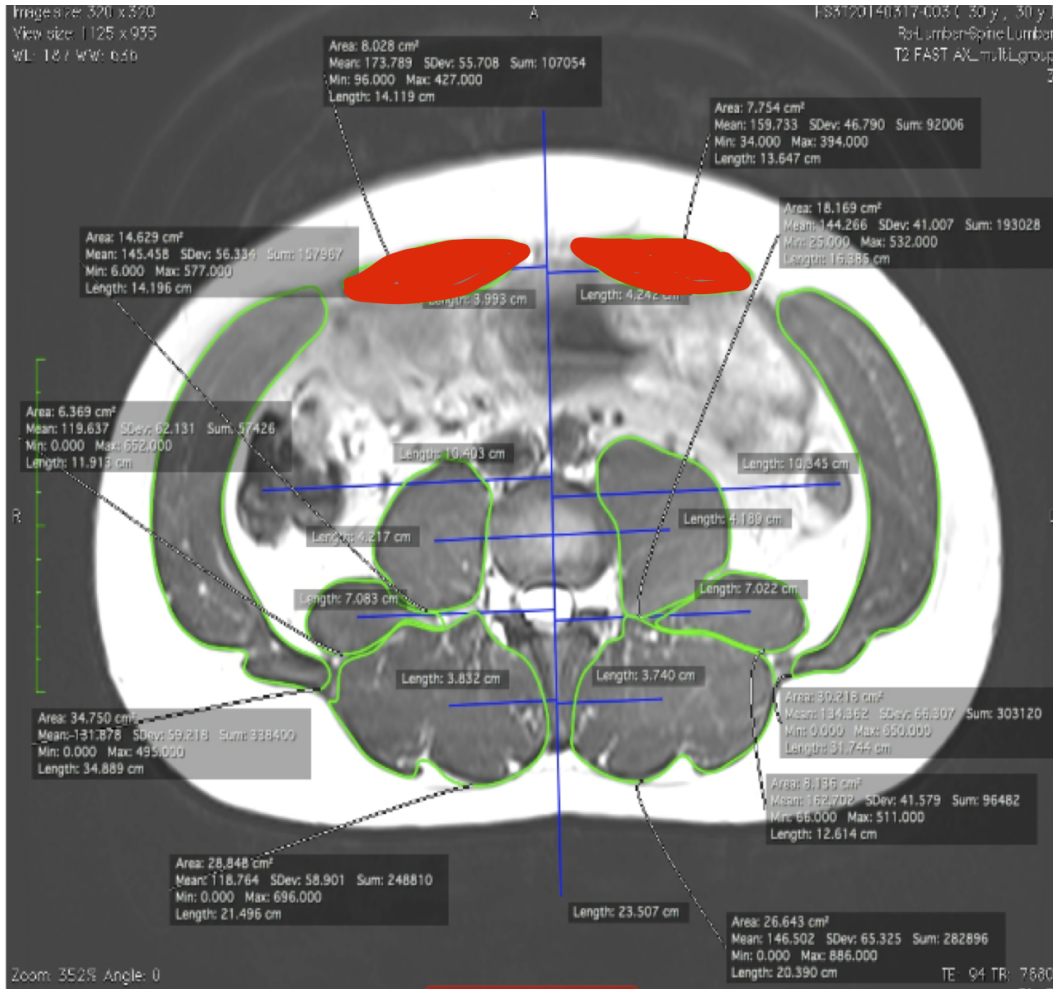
MRI Axial View of the Rectus Abdominus Muscles
